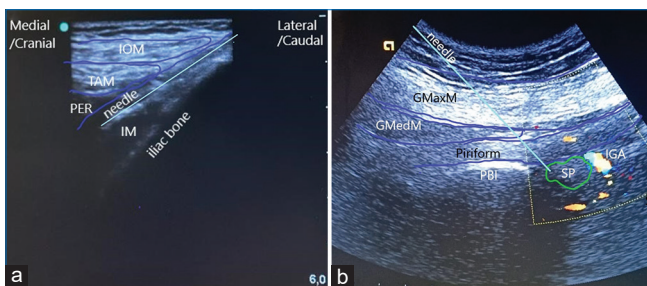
(a) Ultrasound imaging for deep fascia iliaca block. FI = Fascia iliaca; IL = Inguinal ligament; IM = Iliac muscle; IOM = Internal oblique muscle; IP = Injection point; LA = Local anaesthetic; PER = Peritoneum; SM = Sartorius muscle; TAM = Transverse oblique muscle. (b) Ultrasound imaging for the sacral plexus block. GMaxM = Gluteus maximum muscle; GMedM = Gluteus medius muscle; IGA = Internal gluteal artery; PBI = Posterior border of ischium. In this image, the vessel observed deeply to the sacral plexus are probably the internal pudendal artery but is not considered an important landmark for the performance of the block
